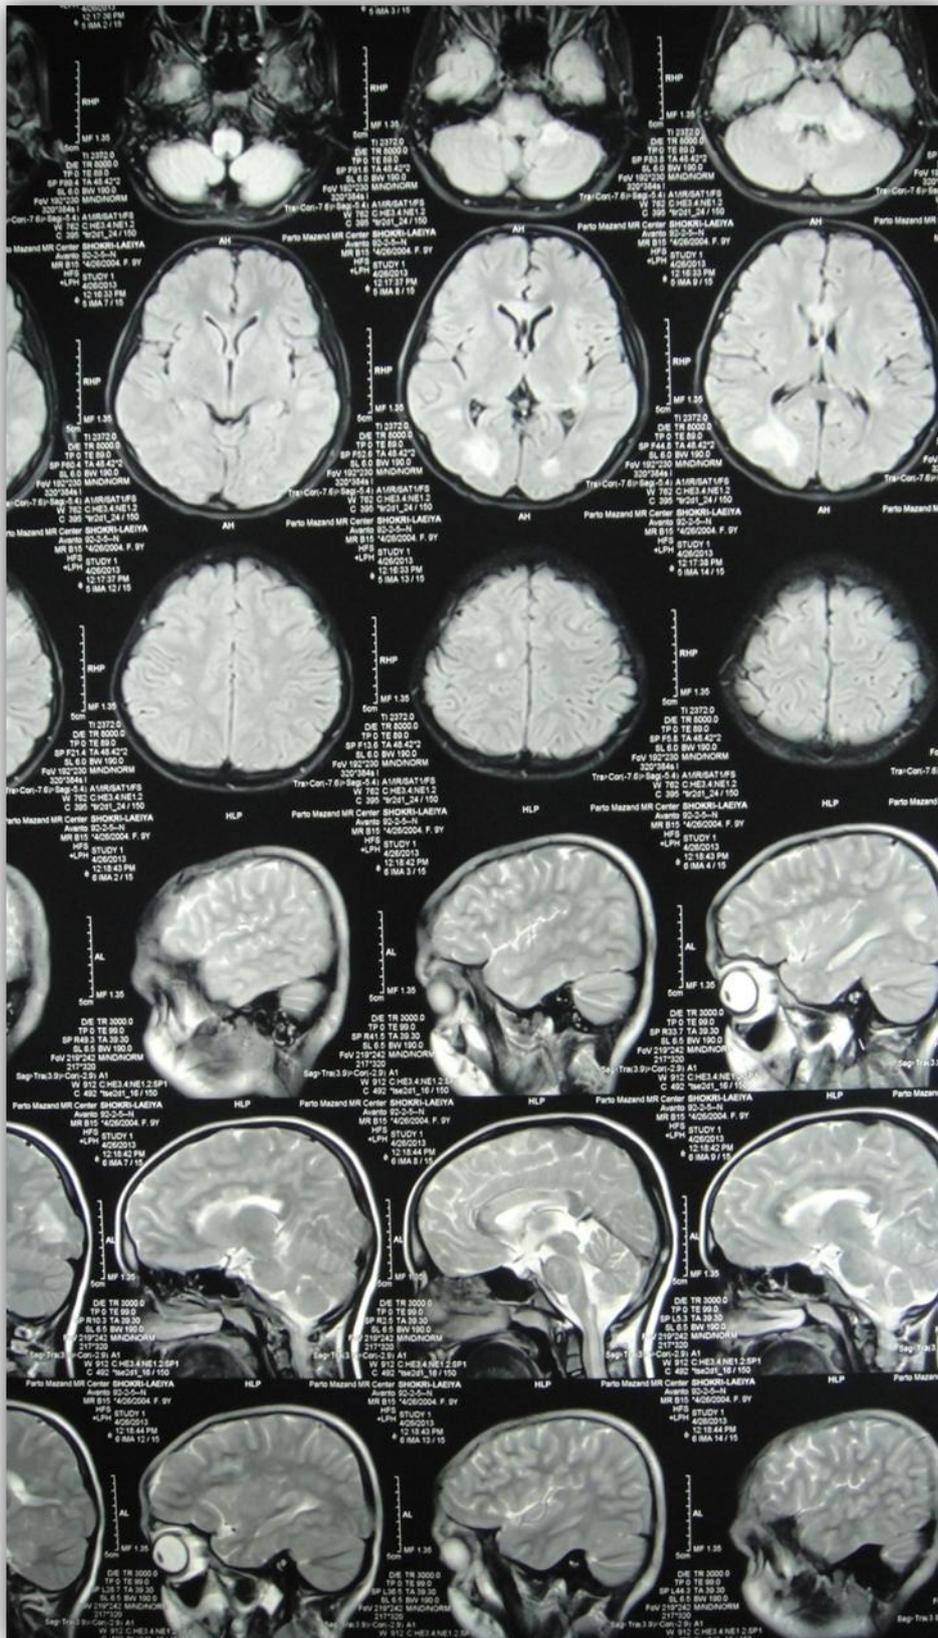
Brain MRI of our patient with ADEM.
